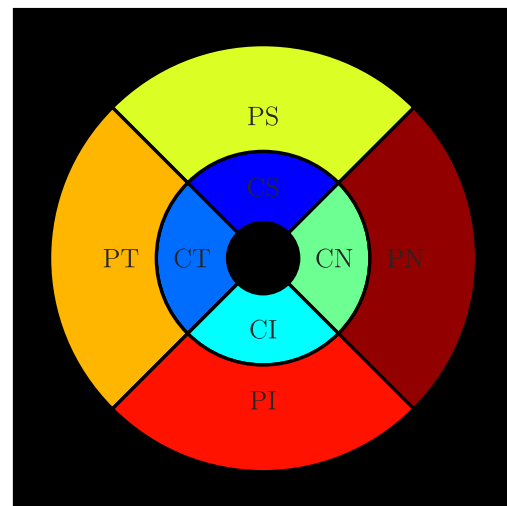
The reproducibility measures were computed in the eight regions shown above, namely, the CS, CN, CI, CT, PS, PN, PI, and PT regions. The *inner*, *middle*, and *outer* circles are 0.2, 0.6, and 1.2 mm in diameter, respectively.
